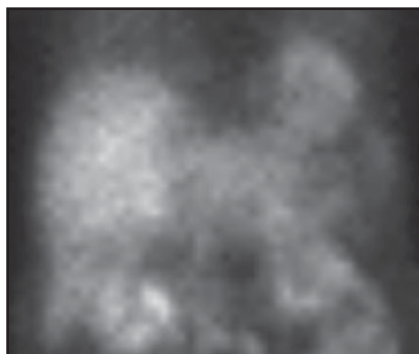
Raw data image from MPI showing lack of gallbladder uptake. Follow-up ultrasound and hepatobiliary scan were consistent with acute cholecystitis.
